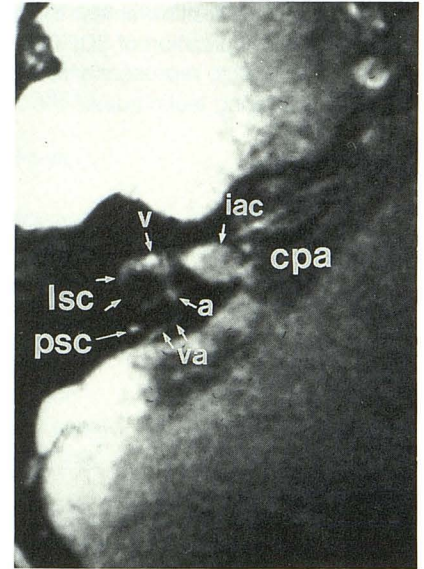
Axial 3DFT MR image at level of right lateral semicircular canal. High-signal endolymph within endolymphatic duct is seen coursing posterior and parallel to posterior semicircular canal (psc) within vestibular aqueduct (va). See key for abbreviations.
